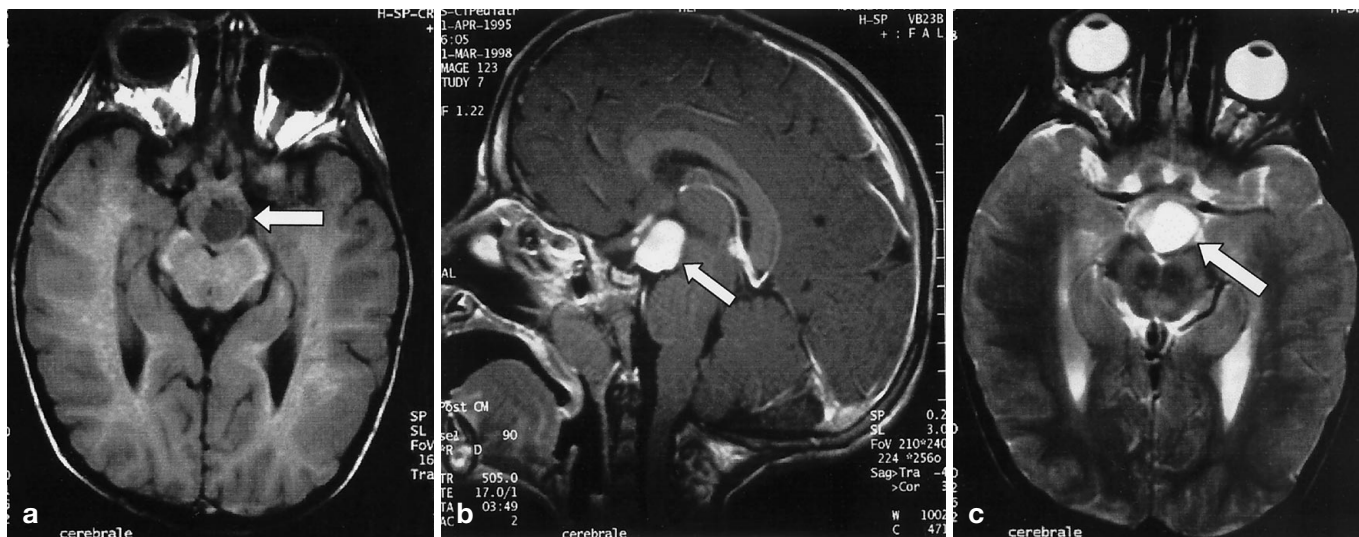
a–c. A 3-year-old NF1 patient with an enhancing mass in the hypothalamus and in the anterior optic pathways. a Unenhanced axial T1-weighted image shows the hypointense mass in the hypothalamus (*arrow*). b Contrast-enhanced sagittal T1-weighted image shows an enhancing mass involving the hypothalamic/chiasmatic region (*arrow*). The optic nerve appears to be enlarged but unenhanced. c Axial T2-weighted image shows the hyperintense mass displacing the chiasma (*arrow*)
